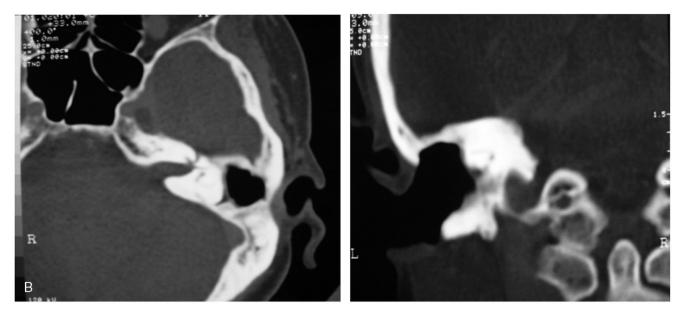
(A) Preoperative temporal bone computed tomography of the patient demonstrating soft tissue filling the left mastoid cavity. (B) Postoperative temporal bone computed tomography of the patient demonstrating the tumor-free mastoid cavity.
